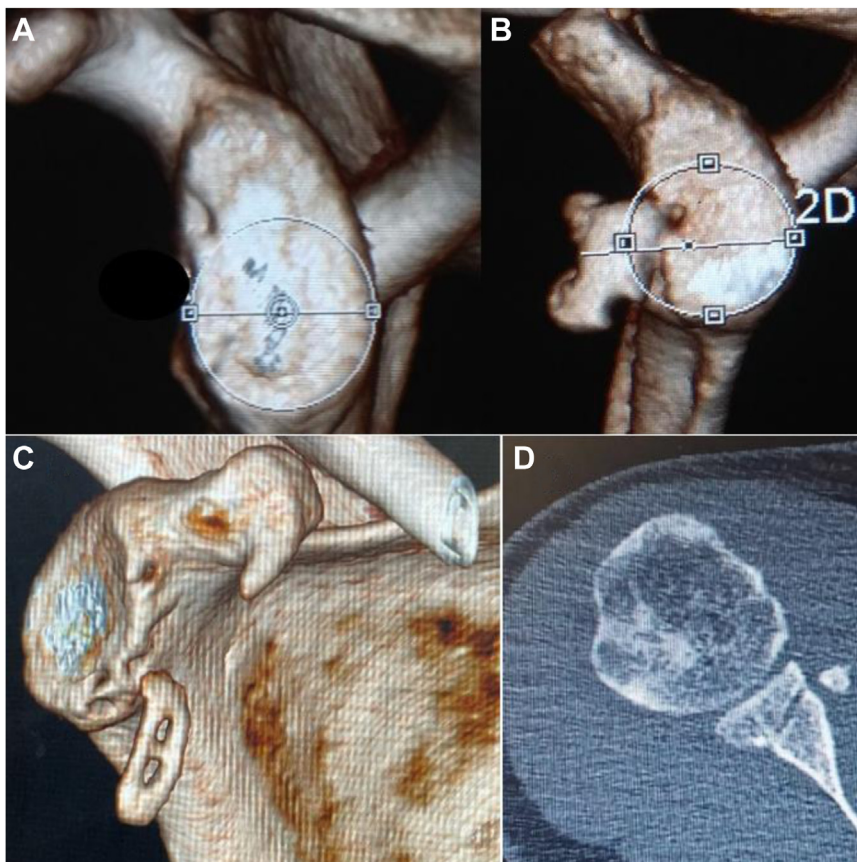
(A) Preoperative CT scan with glenoid bone loss. (B) Three-month follow-up CT after surgery demonstrating well-positioned and united coracoid graft. (C and D) Coracoid graft loosening with migration in a 3-month postoperative CT scan. CT, computed tomography.
